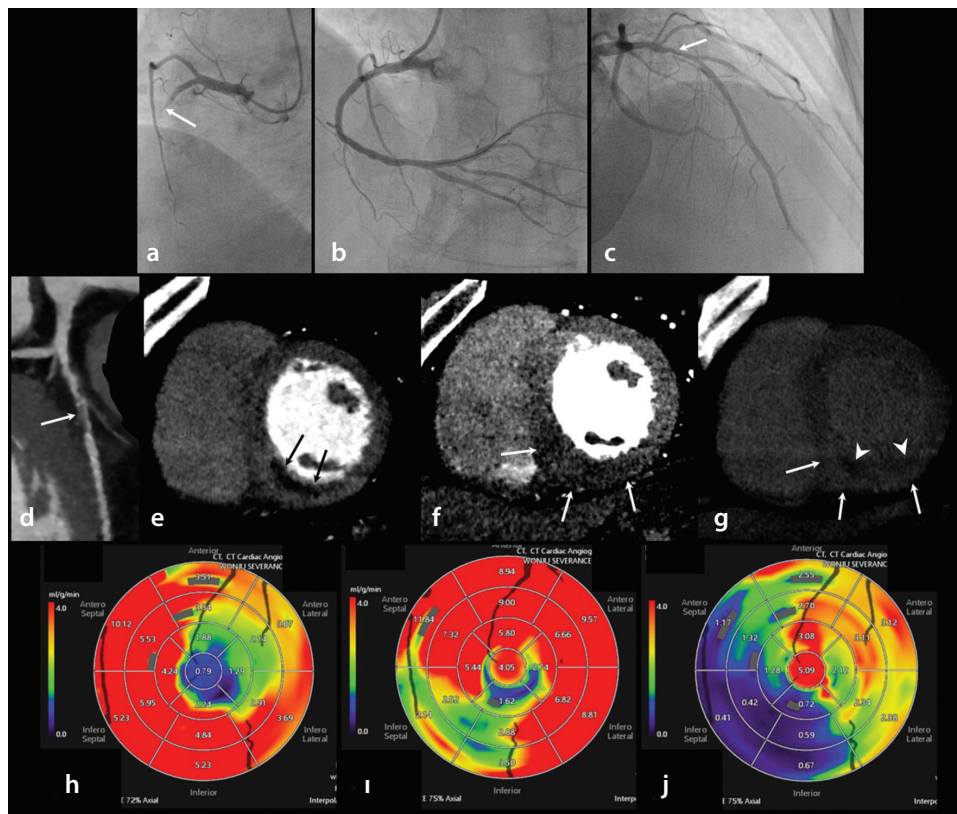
Dynamic CT-MPI to assess the hemodynamic significance of non-infarct-related arteries in reperfused STEMI. (a–c): Invasive coronary angiography shows complete thrombotic occlusion of the proximal RCA (a, arrow), successfully treated with PCI (b). A non-culprit lesion with approximately 70% luminal narrowing is noted in the proximal LAD (c, arrow). (d): Curved MPR CCTA image shows significant (> 70%) stenosis with non-calcified plaque in the proximal LAD (arrow). (e, f): Dynamic stress (e) and rest (f) CT-MPI shows more pronounced perfusion defects during stress than at rest in the mid-inferior and inferoseptal LV segments (arrows), with no perfusion defects in the LAD territory. (g): Myocardial delayed-enhancement short-axis MPR CT image demonstrates transmural delayed enhancement (arrows) with subendocardial non-enhancing areas consistent with MVO (arrowheads) in the RCA territory, indicating acute transmural MI. (h–j): Polar maps of dynamic stress (h) and rest (i) CT-MPI examinations and CFR (j). Per-segment CFR_{CT} is calculated as the ratio of hyperemic MBF_{CT} to resting MBF_{CT} . A CFR_{CT} image of the antero-septal LV wall is reduced (< 1.4) compared with the lateral LV wall (> 2.0). Using the optimal CFRCT cut-off value of 2.0, ischemia is seen in the LAD territory. Invasive FFR was 0.75 in the proximal LAD. Staged physiology-guided PCI was performed on the proximal LAD, and the FFR was increased to 0.91 (not shown). CT, computed tomography; MPI, myocardial perfusion imaging; STEMI, ST-segment elevation myocardial infarction; MPR, multiplanar reformation; LV, left ventricular; CCTA, coronary CT angiography; RCA, right coronary artery; LAD, left anterior descending coronary artery; PCI, percutaneous coronary intervention; MVO, microvascular obstruction; CFR, coronary flow reserve; MBF, myocardial blood flow; FFR, fractional flow reserve.
